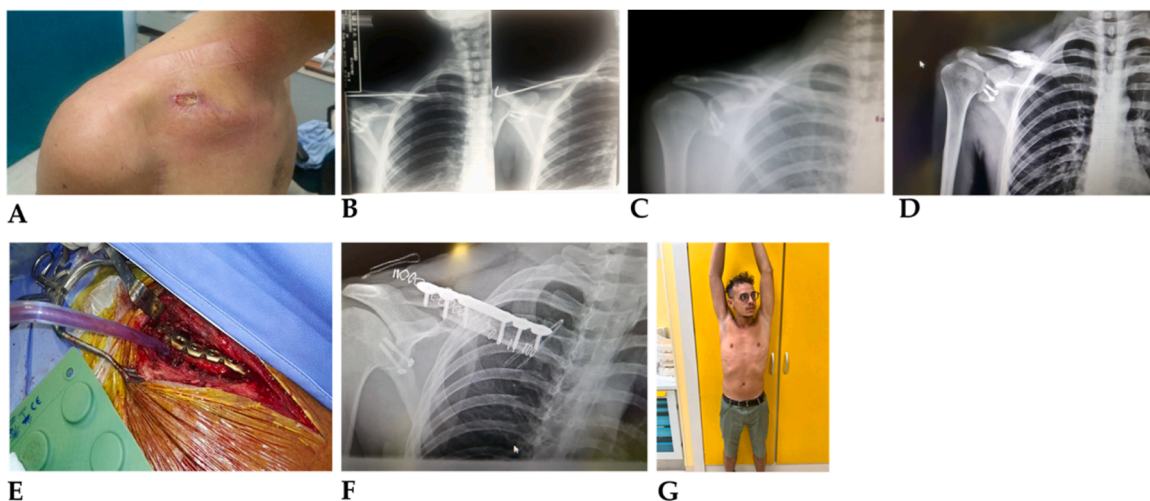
A: clinical presentation under our observation; B: RX at our observation; C: X-ray after removal of the Kirschner wire; D: X-ray after surgical toilet and interposition of antibiotic cement; E: intraoperative images: surgical toilet and preparation of fracture heads for reduction and synthesis with plate and screws and opposing bank bone splint; F: post-operative x-rays; G: 1-year clinical follow-up.
